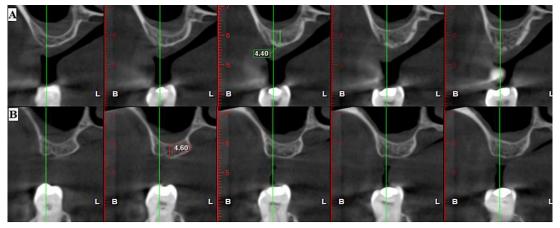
A: Pre-OP CBCT showing bone height with 16; B: Pre-OP CBCT showing bone height with 17
